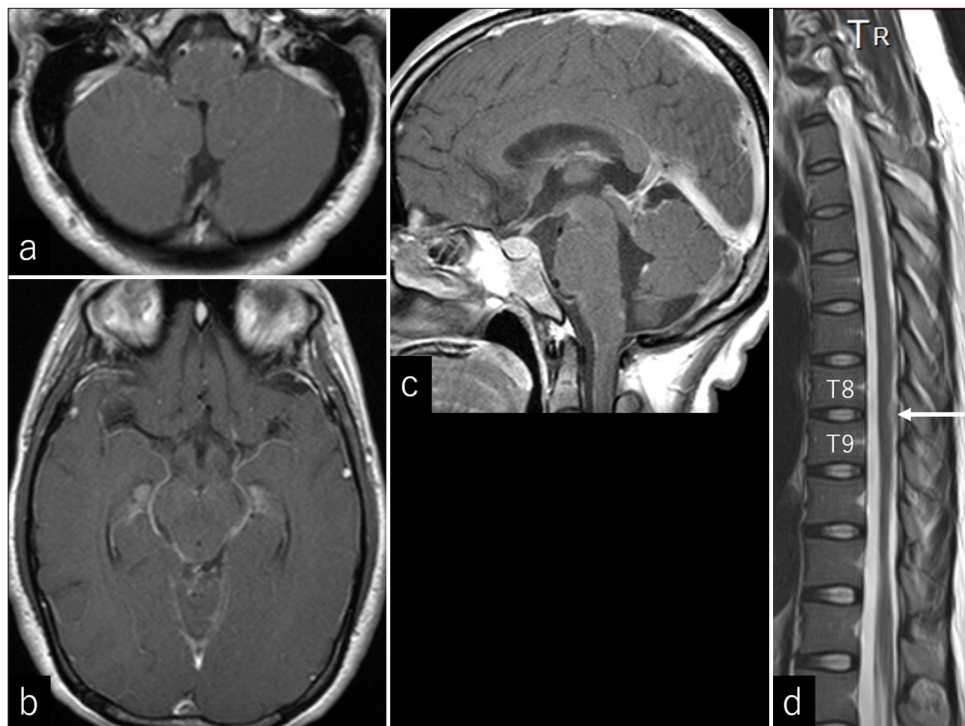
(a and b) Postcontrast axial magnetic resonance imaging at the levels of the medulla oblongata (a) and upper midbrain (b), showing no abnormal enhancements in the cranial cavity. (c) Postcontrast sagittal cerebral magnetic resonance image showing subtle leptomeningeal enhancements along the brainstem and fourth ventricle. (d) Sagittal T2-weighted spinal magnetic resonance image showing a small nodular lesion at T8/T9, on the dorsal surface of the cord (arrow).
